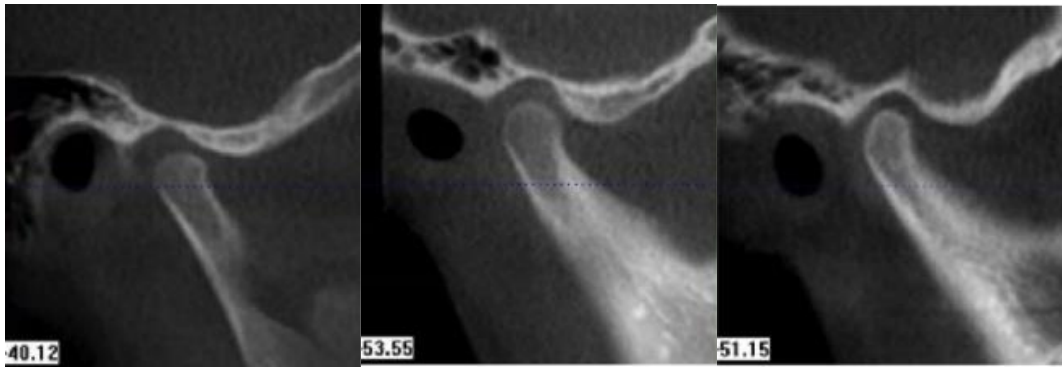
Types of mandibular condyle correction in the sagittal cone-beam computed tomography (CBCT): Type I, Type II, Type III
